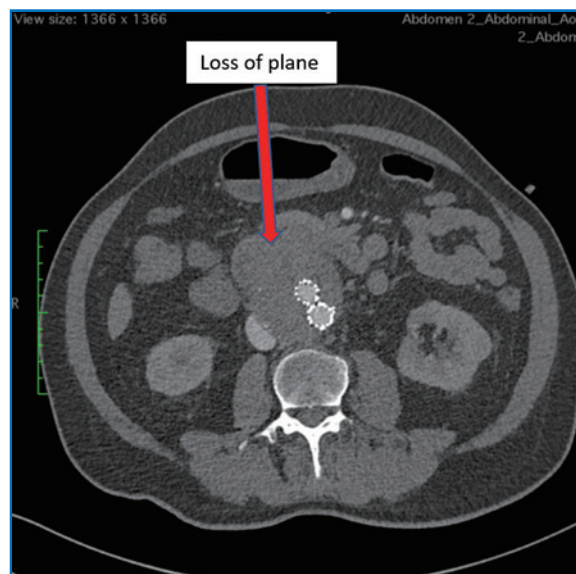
CT at presentation of PR bleeding (Clinical photo from personal collection)
